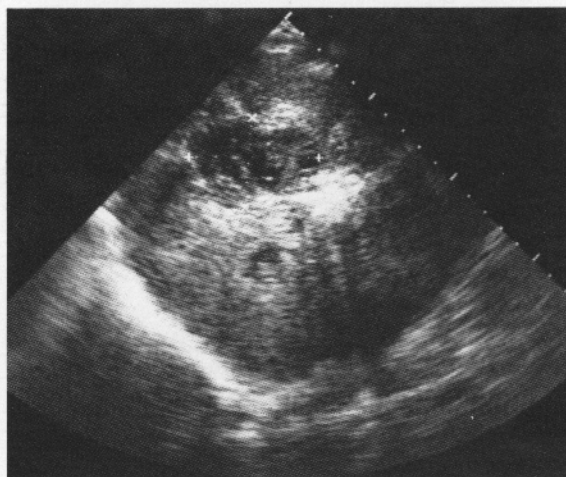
Ultrasound scanning (USS) of the liver showing intrahepatic cavity in the right lobe of the liver.
